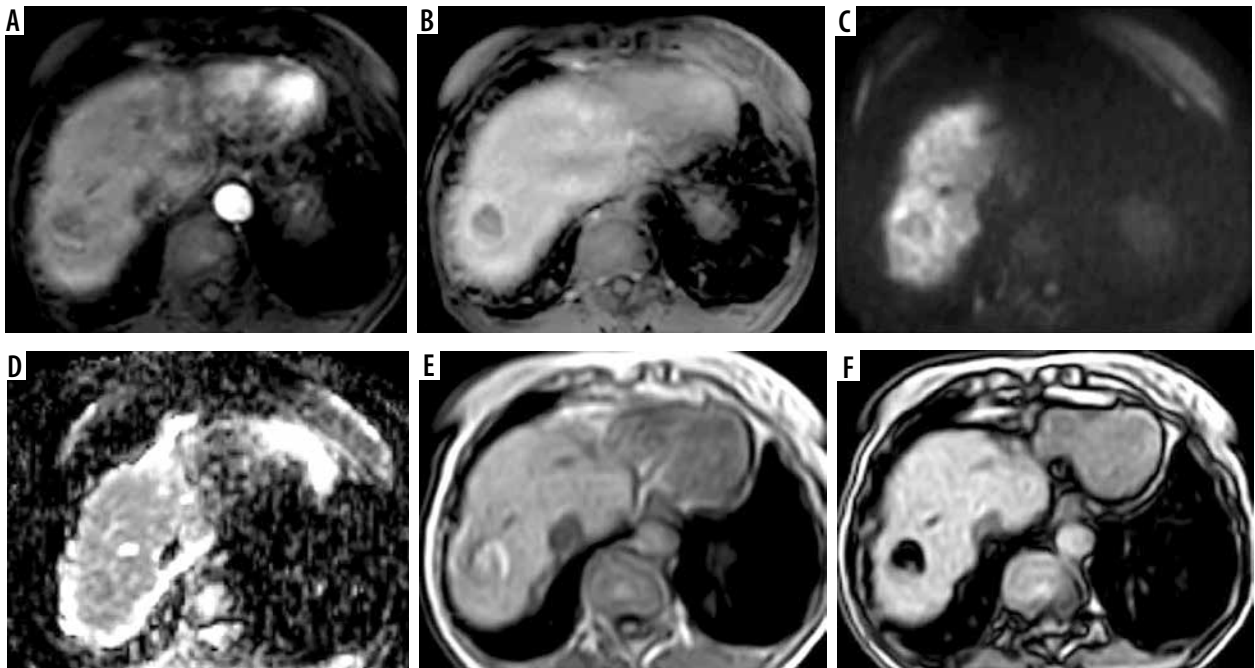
LR-4. A) Arterial phase image shows hepatic focal lesion at sub-segment VIII with arterial hyperenhancement. B) Delayed phase shows no evidence of washout with enhancing capsule. C, D) Diffusion-weighted imaging (C) and ADC (D) show no diffusion restriction. E, F) T2-weighted image (E) shows bright signal fat that shows loss of signal in the out of phase image (F)
